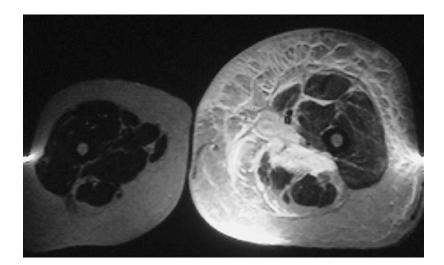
Lymphedema of the left upper leg in a 48-yearold woman, with a history of vulval carcinoma treated with surgery and radio- and chemotherapy. Axial turbo spin echo T2-weighted MR image. There is an important thickening of the subcutaneous fat secondary to lymphedema, probably as a consequence of the intrapelvic surgery. Note the important increase in volume of the left thigh compared with the contralateral leg. An inflammation of the left adductor muscles can also be seen
